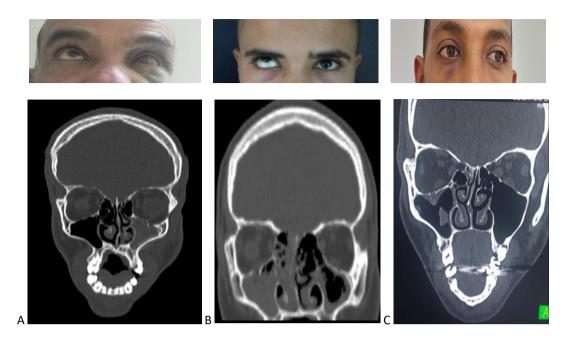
(A): At the top photograph of a man with a fracture of the left orbital floor with left periorbital bruise, horizontal diplopia with high vision. Below, TDM in a bone window and in the coronal cut showing a fracture of the floor of the left orbit in Trap-Door with incarceration of the lower right muscle and homolateral hemosinus. (B): at the top photograph of a man with enophthalmos, a right vertical diplopia, below, CT of the facial massif in a bone window and in coronal cut showing a fracture of the floor of the right orbit with incarceration of the infected right muscle, right hemosinus (C): Photography of a man with a fracture of the right orbital floor with enophthalmia and a right orbital board fracture
